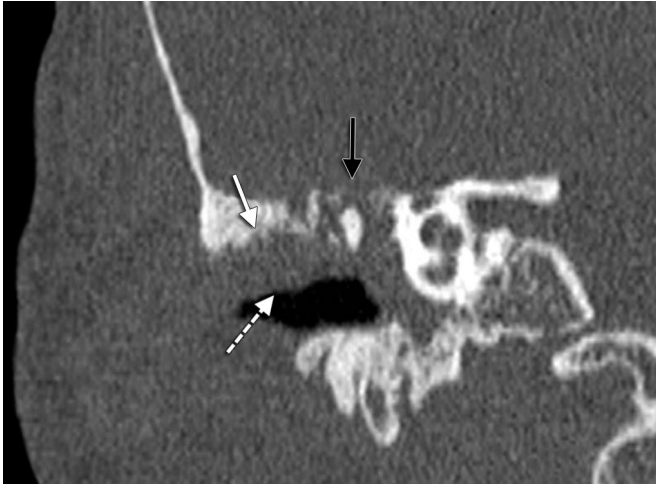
Necrotizing external otitis. Noncontrast coronal CT image of the right temporal bone demonstrates marked soft tissue swelling overlying the EAC with soft tissue within the EAC (dashed arrow) and middle ear cavity. There is erosion of the EAC (solid white arrow) and tegmen tympani (black arrow).
